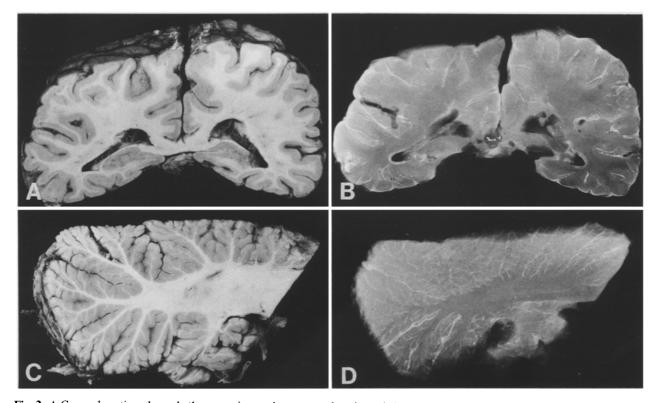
A Coronal section through the posterior parietotemporal region of the brain. The leptomeninges are blurred, the cortex narrow, and the ventricular wall granular. B X-ray of same region as A. Calcifications are visualized as white streaks following the arachnoidea-pia and running from the leptomeninges through the cortex to centrum semiovale, as fine white dots in the white substance and as a narrow band limiting the posterior horns. C The left cerebellar hemisphere. Blurred leptomeninges and slightly atrophic gyri are seen. D X-ray of the same region as C. Along the surface and following the vessels fine white streaks of calcifications are noted. White dots revealing calcium compounds in the white matter
